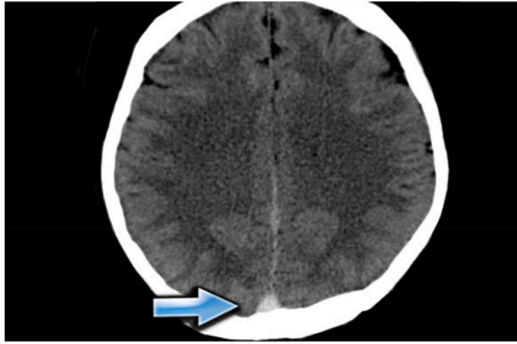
Dense clot sign: also known as the "dense vein sign" refers to direct visualization of a hyperattenuating clot in the cerebral veins on a non-enhanced computed tomography scan. This sign is only visualized in approximately a third of cases. (Cerebral Venous Sinus Thrombosis. Retrieved from: <https://radiologyassistant.nl/neuroradiology/sinus-thrombosis/cerebral-venous-thrombosis>.)
